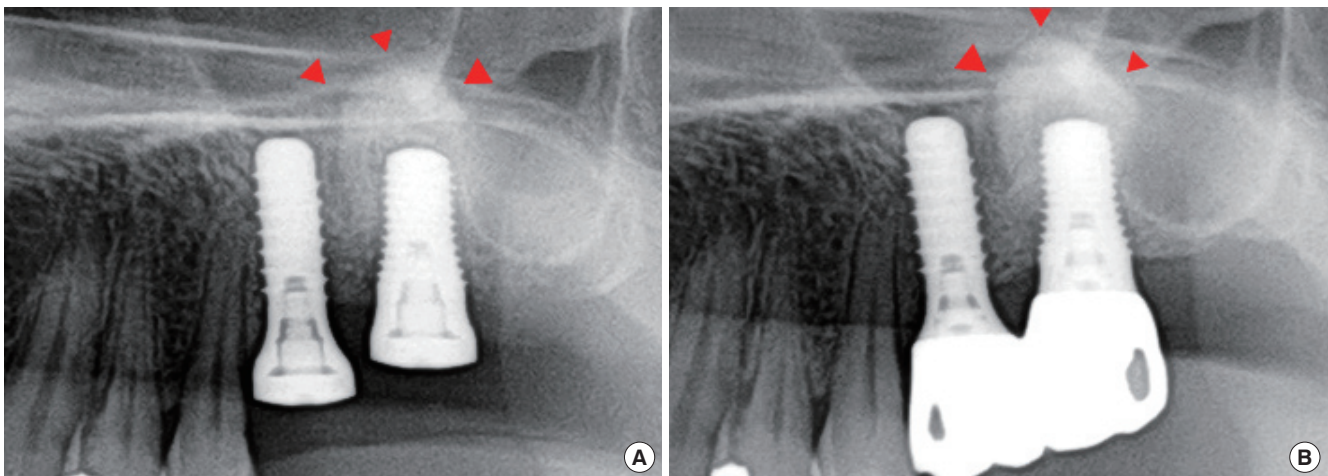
Radiographs on the day of surgery (A) and 27 months after surgery (B). Arrowheads: augmented bone area.
